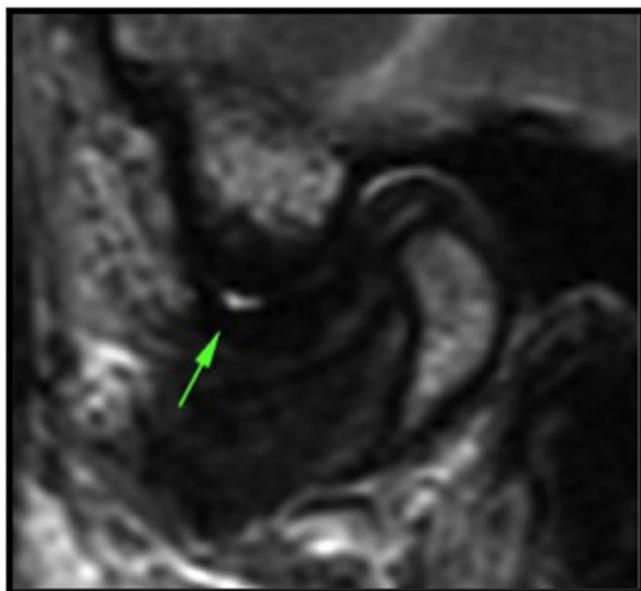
MRI: Sagittal plane, T2-weighted image. TMJ presenting joint effusion (arrow).
